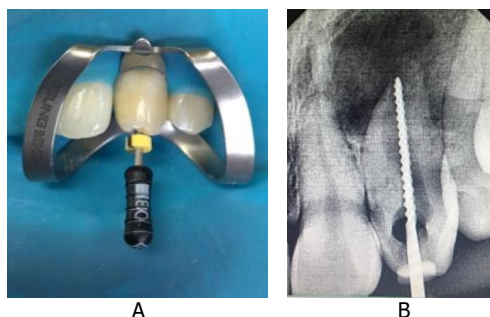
A. Measurement of working length; B. Radiographic confirmation of working length
